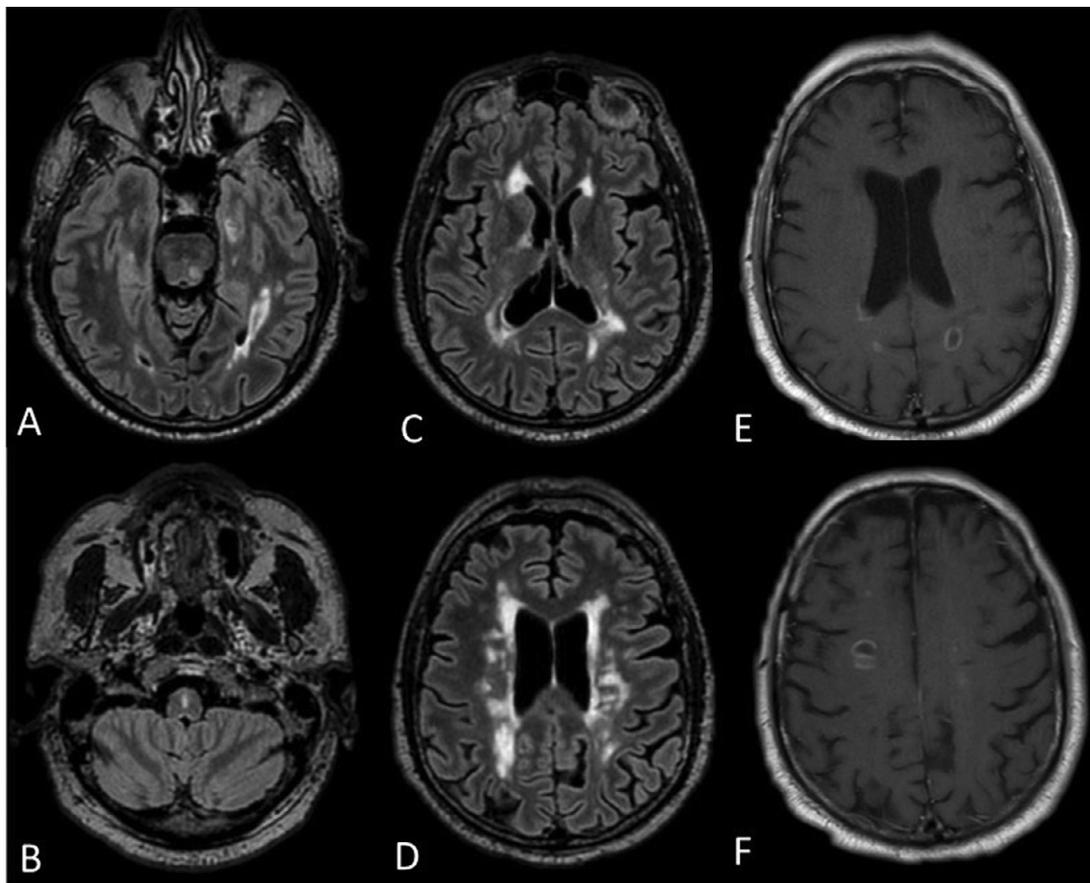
MRI Findings in 2017: MRI scans in 2017. The FLAIR-weighted sequences of the brain (A, B, C, D) show new hyperintense lesions of the subcortical white matter, corpus callosum, bilateral semioval center, right thalamus, midbrain and pons. The T1-weighted sequences with Gadolinium (E, F) show multiple GE lesions.
